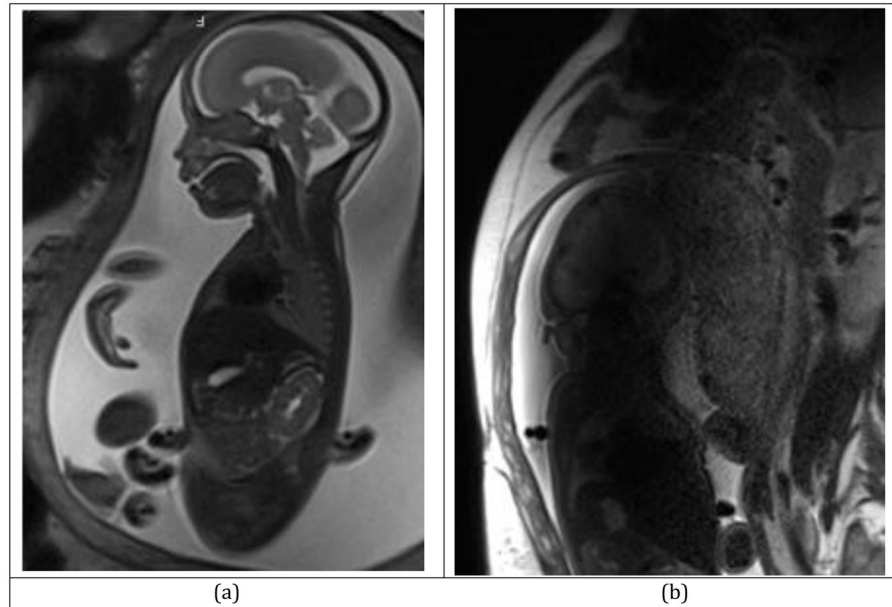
SST2W MRI scan on a Siemens Skyra 3T scanner; with TR=2s, TE=121ms, ETL=109, FA=153, number of averages=1, Slice thickness: 3mm, Acquisition matrix: 256×256: (a) high-quality SST2W fetal MRI acquired at 3 Tesla, (b) Fetal MRI degraded by RF penetration and conductivity artifact, which occasionally degrades the fetal MRI scans at 3T. A multi-transmit system may reduce this artifact by generating a more homogeneous B_1 field across the FOV. A dielectric pad may be used to do the same.
